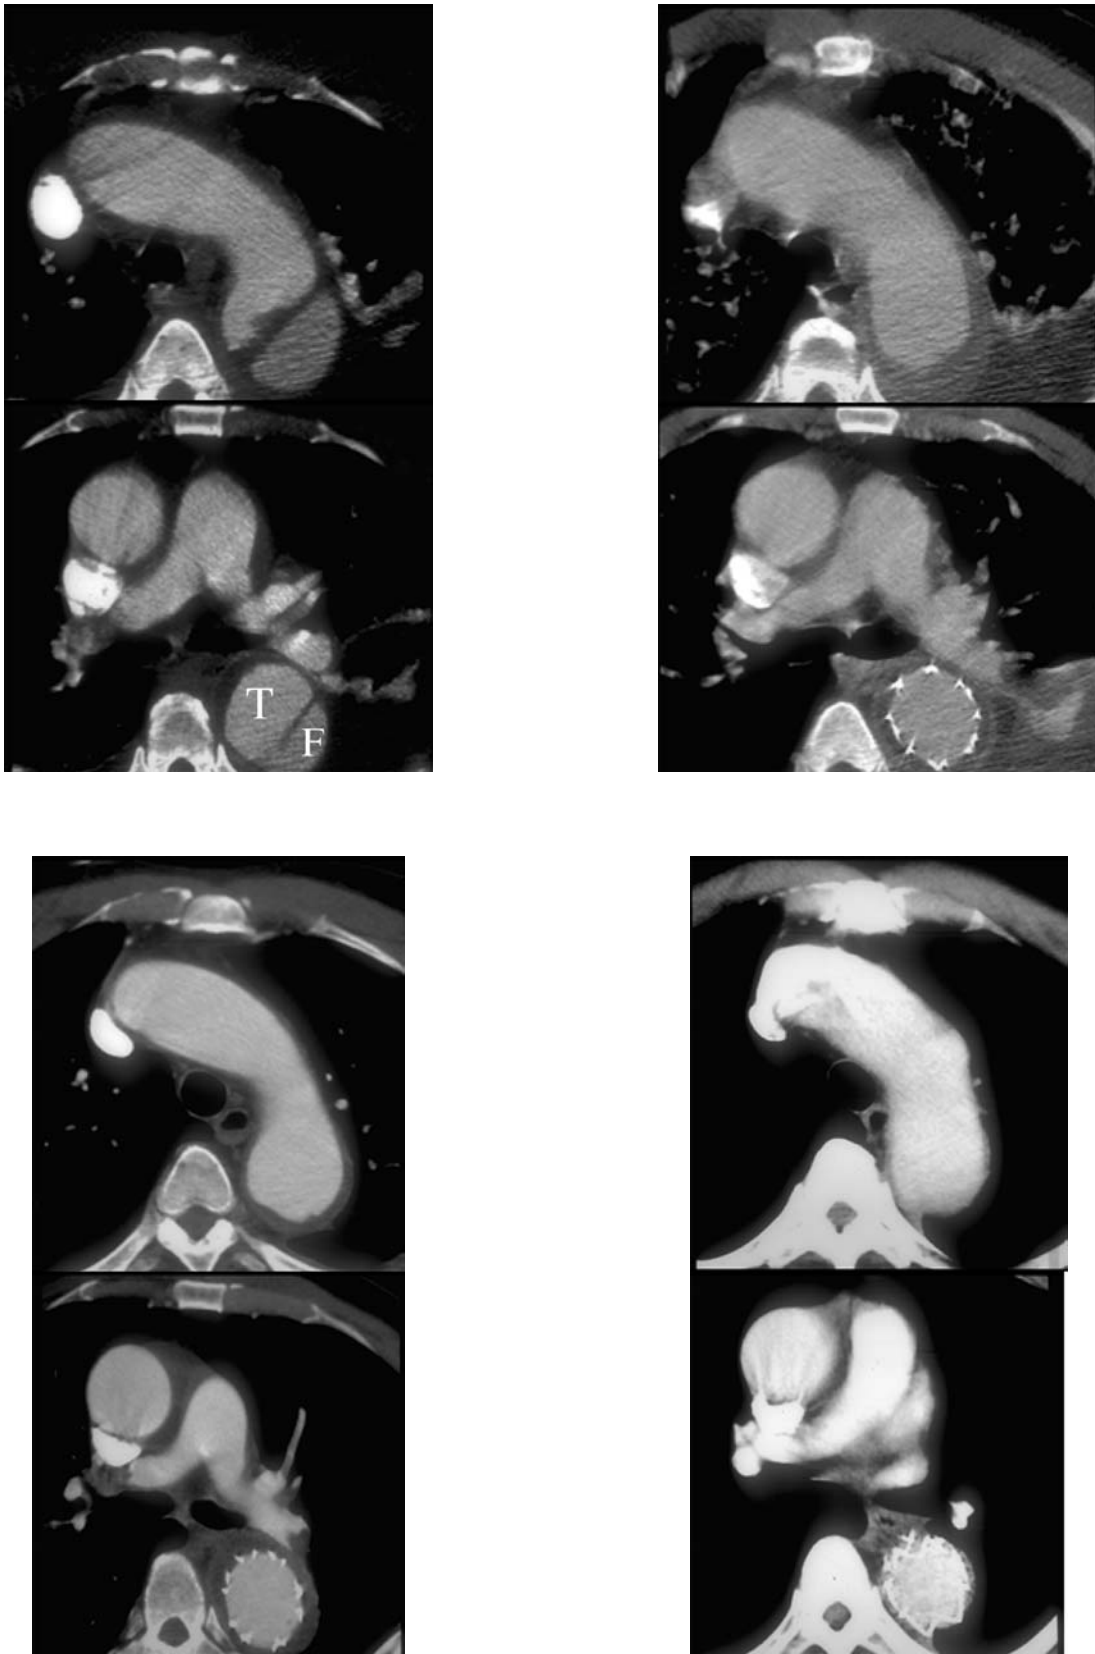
Series of CT scans performed at the same anatomic levels before and following stent-graft repair of a 53-year-old man with an acute type B aortic dissection complicated by abdominal branch vessel involvement. Immediately after stent-graft placement, there is an increase in the size of the true lumen (T) with resolution of the peripheral ischemia, and subsequently, progressive thrombosis and shrinkage of the false lumen (F).
